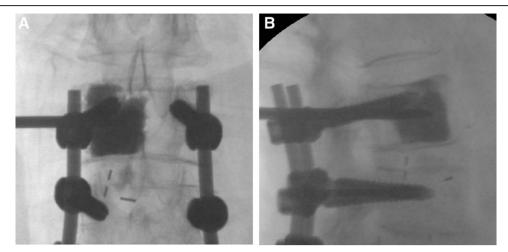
Intraoperative C-arm fluoroscopy images. A and B, AP and lateral X-ray showed the bone cement filling the anterior two-thirds parts of the body. AP = anteroposterior.
